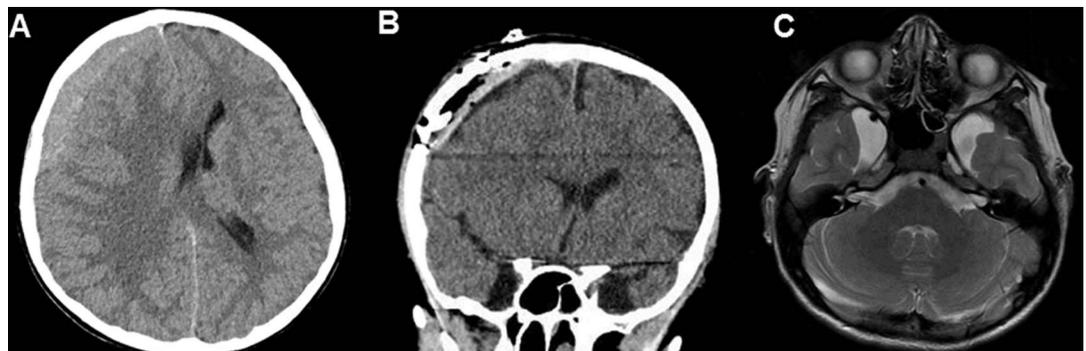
(A) Non-contrast axial CT reveals subdural haemorrhage of mixed signal intensity with midline shift. (B) Postoperative CT showing resolution of subdural haemorrhage with postoperative changes and bitemporal arachnoid cysts. (C) Axial T2-weighted MRI demonstrating bitemporal arachnoid cysts.
